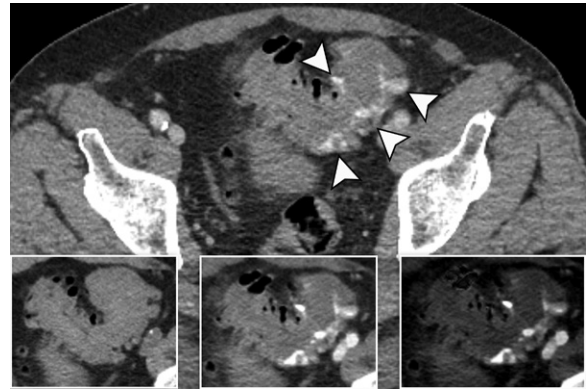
Acute diverticular bleed in the sigmoid colon on dual-energy CT images in a 72-year-old man who presented with bright red blood in the rectum. Axial portal venous phase mixed (blended) CT image (main image) shows multiple foci of contrast extravasation in the sigmoid colon (arrowheads) and diffuse sigmoid diverticulosis, some containing extravasated contrast material. Axial noncontrast CT image (left inset) shows hyperattenuating bowel contents in the sigmoid colon. Axial postprocessed monoenergetic 50-keV image (middle inset) and iodine map image (right inset) show contrast extravasation that is more conspicuous at the lower kiloelectron voltage setting and on the iodine map than on the mixed (blended) image.
